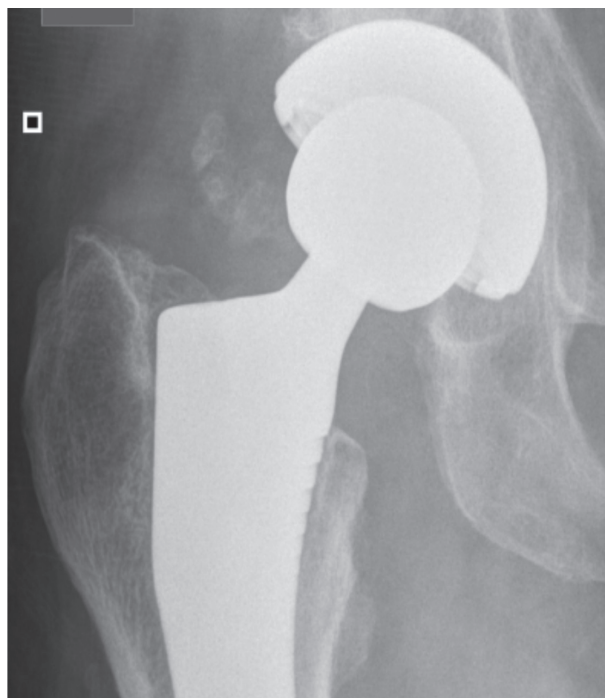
One year post-operative xray showing HO Class I Brooker's
